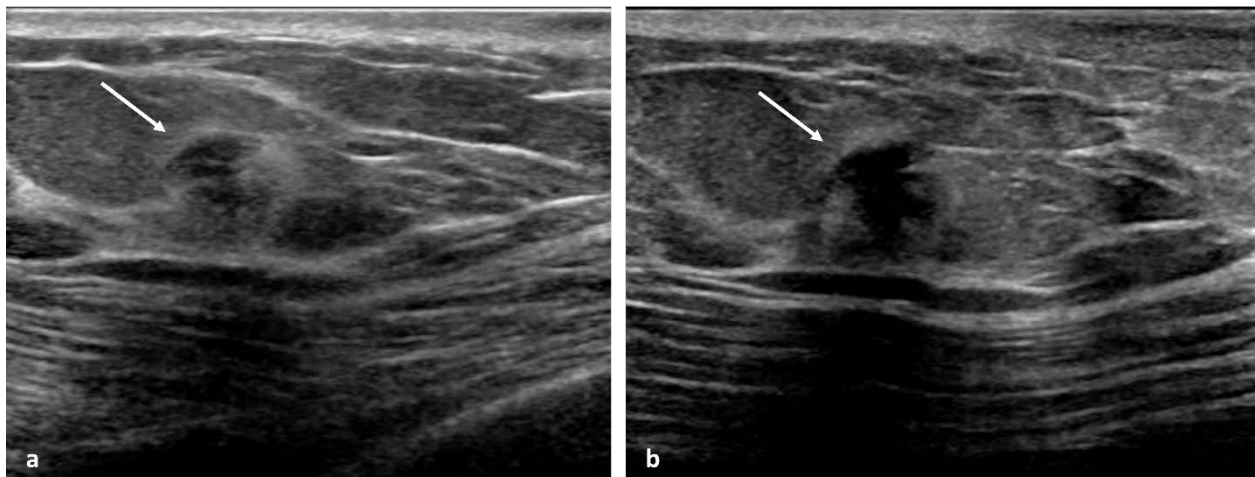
Anisotropy: Two serial ultrasound images in the radial orientation. The internal echogenicity of the granular cell tumor changes significantly with a small tilt of the probe.
